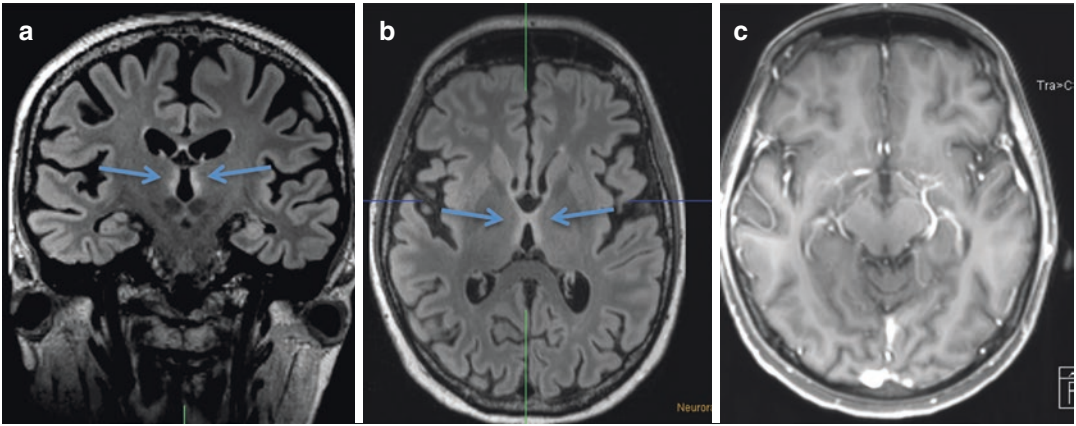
A 43-year-old man complained of blurred vision since 3 months. Three days ago, he suffered a sudden loss of visual acuity with central scotomas. He said to consume 2.5 L beer and 0.5 l wine/day. MRI shows Wernicke
